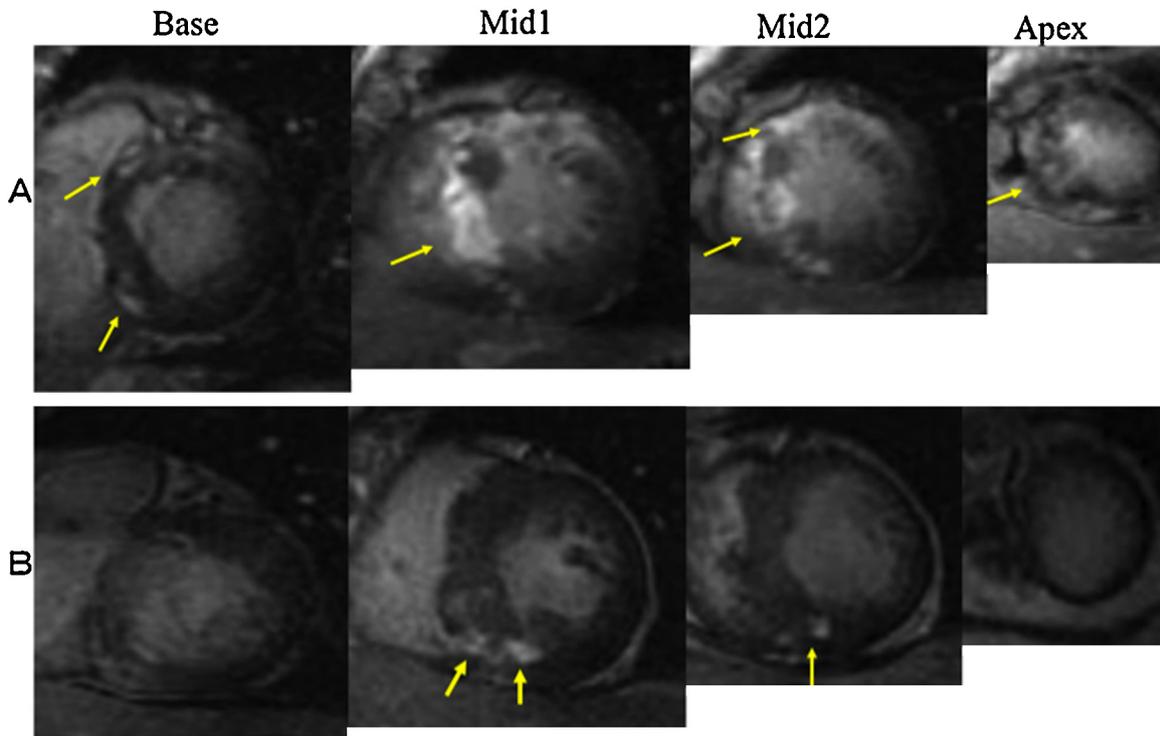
Representative magnetic resonance imaging in patients with hypertrophic cardiomyopathy (HCM) with (A) or without (B) ventricular tachyarrhythmias. (A) The image was obtained from a 52-year-old female with the late gadolinium enhancement (LGE) (arrows) extent of 37.6%. The thickness of interventricular septum was 14 mm. (B) The image was obtained from a 35-year-old female with the LGE (arrows) extent of 6.5%. The thickness of interventricular septum was 15 mm.
